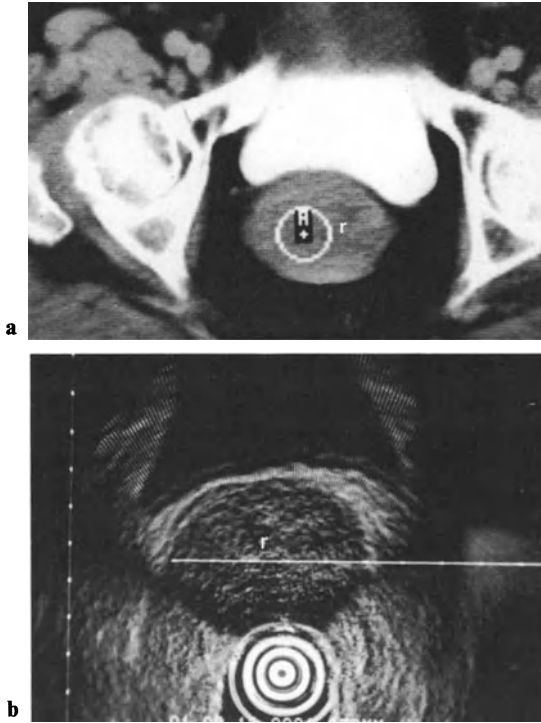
a, b. CT and RS: local recurrence (*r*) after hysterectomy for carcinoma of endometrium
